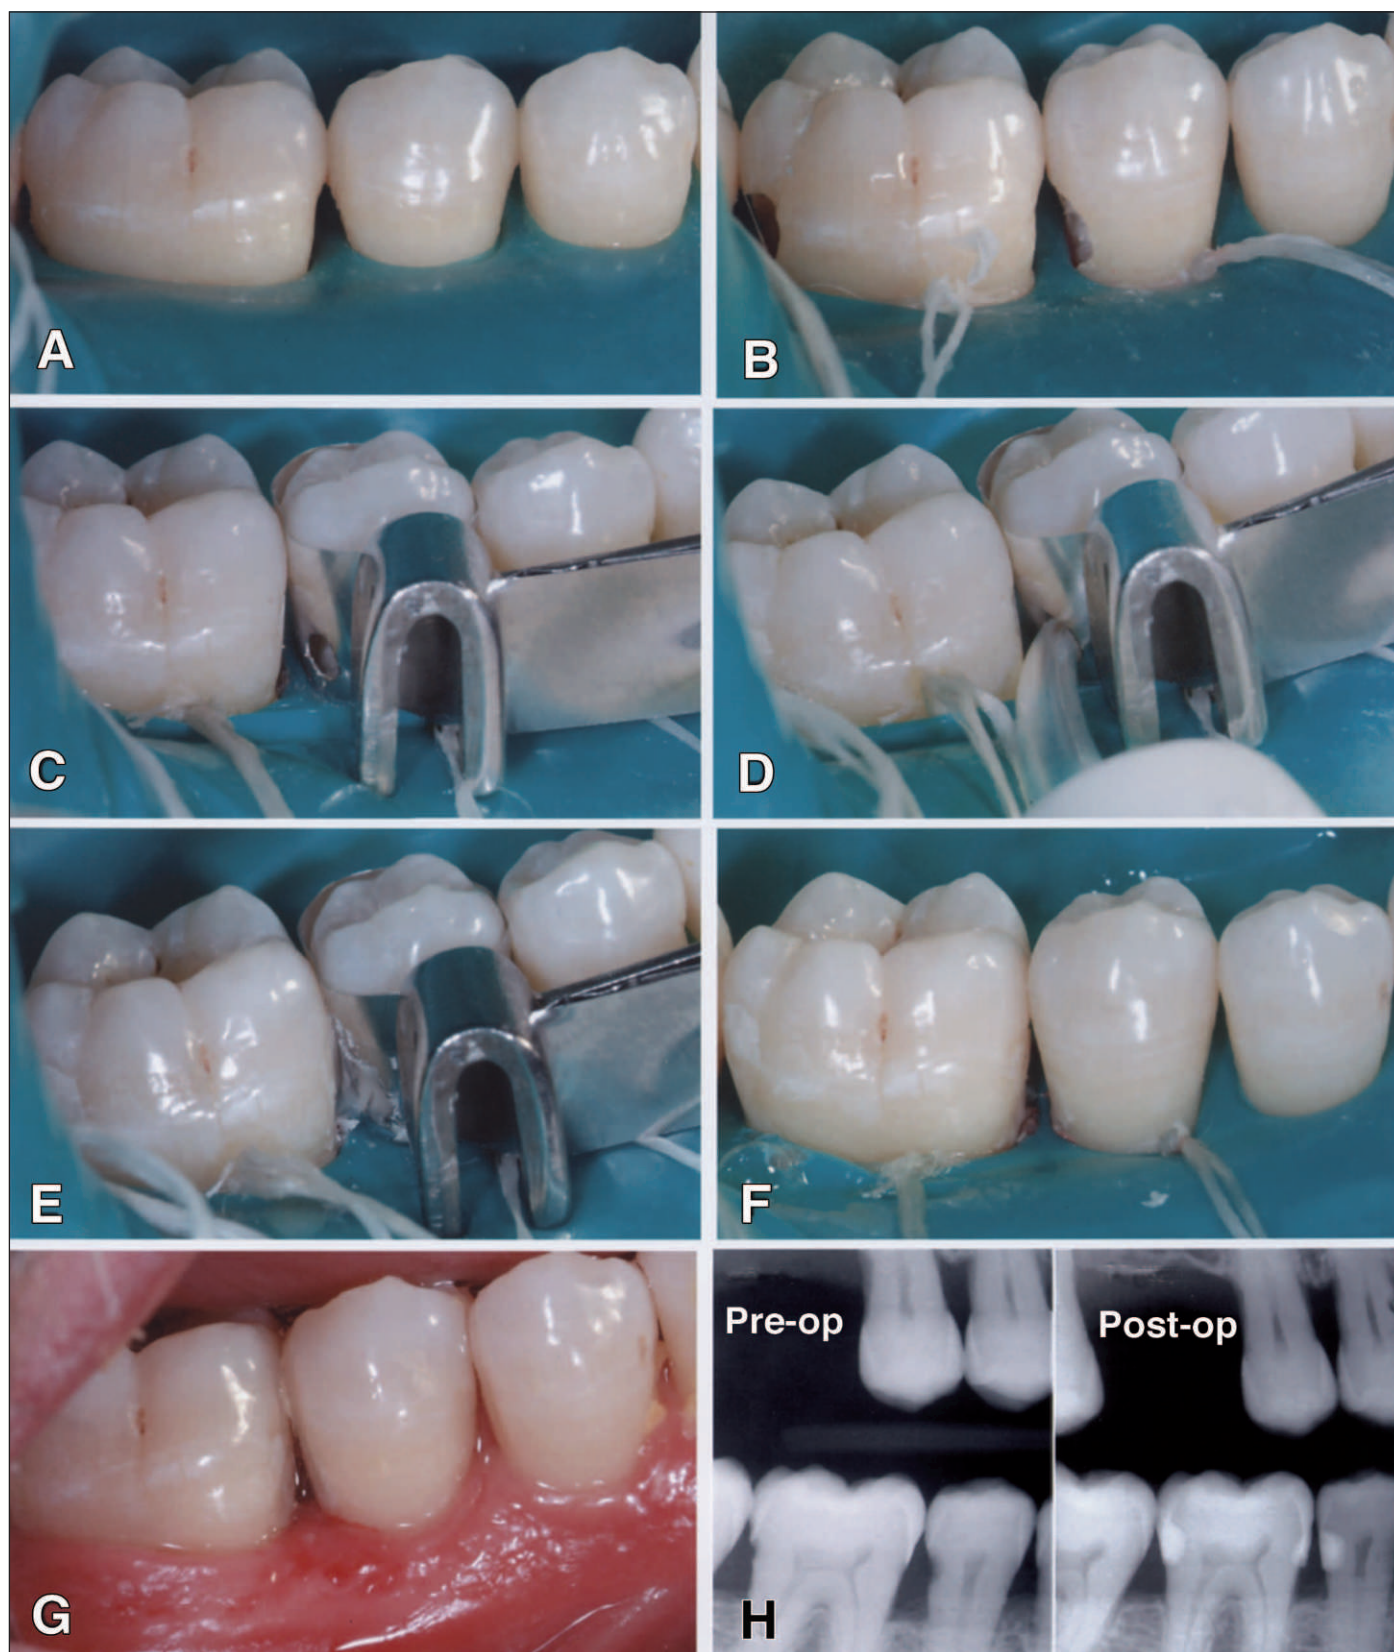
Figure 1. A. Rubber dam placement (retainer on 2nd molar not visible in photograph). B. Placement of floss ligatures and cavity preparation on tooth #29. C. Matrix in place with access hole. D. Tip of the glass ionomer capsule in position. E. Material placed in preparation. F. Contoured restoration on the first day. G. Finished restoration one week later. H. Pre- and post-operative radiographs.
